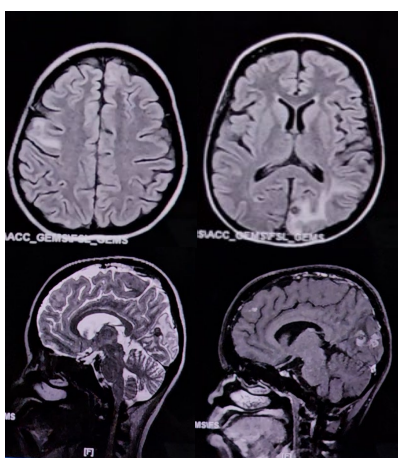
Contrast-Enhanced Brain MRI (Axial and Sagittal Views)
